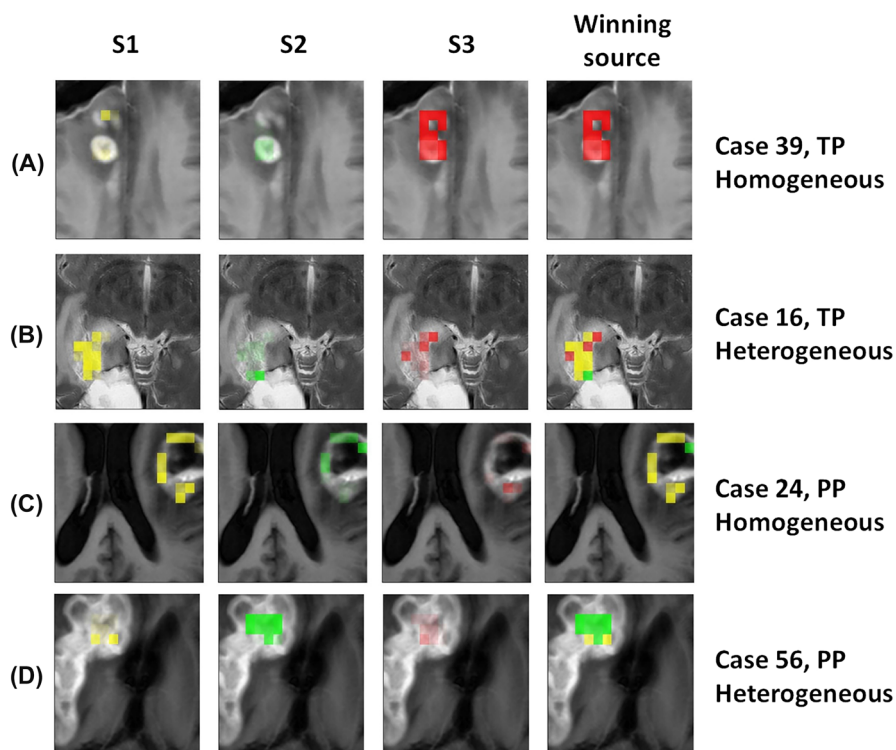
Four representative cases for the three-source extraction. Maps are overlaid onto contrast-enhanced T1-weighted image reference.
